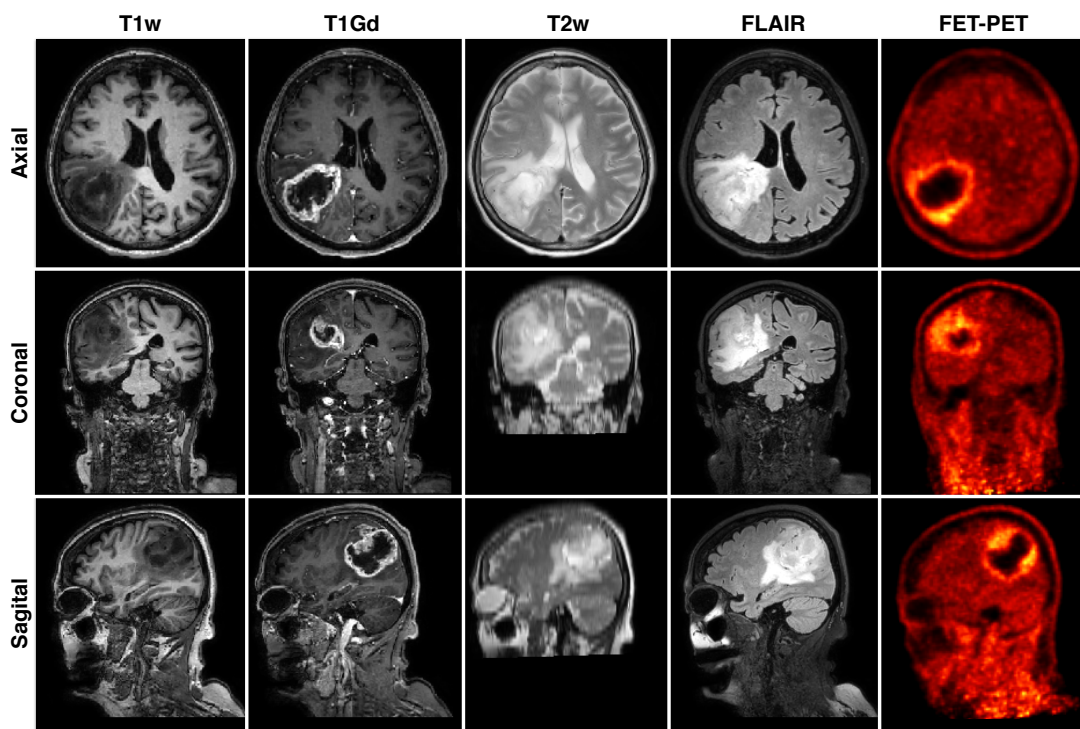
The multimodal scans of a patient diagnosed with glioblastoma. The T1w scan shows a good contrast between brain anatomies, while the tumor appears relatively dark. The T1Gd scan enhances active parts of the tumor, while the dark region enclosed by the enhancing tumor corresponds to the necrotic core. The T2w scan enhances fluid-rich structures. Similar intensities in the edema and CSF complicates delineation of the tumor close to the ventricles. The signal from the CSF is suppressed in the FLAIR scan, allowing a clear differentiation between the edema and ventricles. The FET-PET scan enhances active parts of the tumor. The necrotic core appears dark since the dead cells do not take up the tracer.
